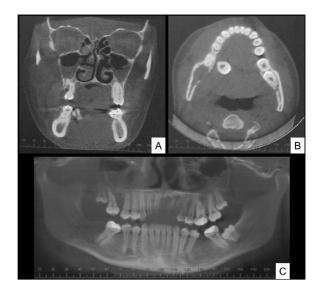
Computed tomography features of a giant cell-rich osteosarcoma of the mandible. (A) Coronal section showing a mass in the right posterior mandible with soft tissue extensions. (B) Axial section showing expansion and bony destruction of the lingual cortical plate, as well as displacement of an adjacent dental unit. (C) Panoramic view exhibiting an osteolytic lesion on the right side of the apex of the second molar and in the region of the third molar.
